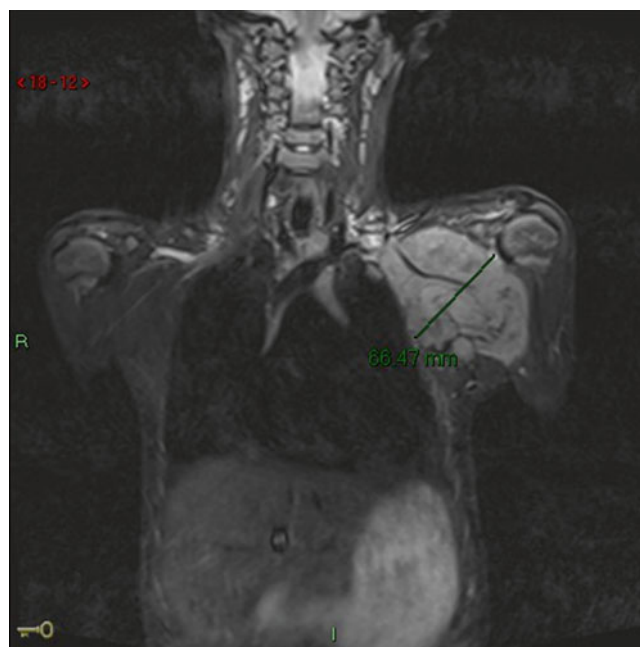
Coronal plane MRI scan of an epithelioid sarcoma of the axilla with the axillary vessels passing straight through the tumour. This tumour could not be treated with limb salvage and the child underwent a modified fore-quarter amputation
